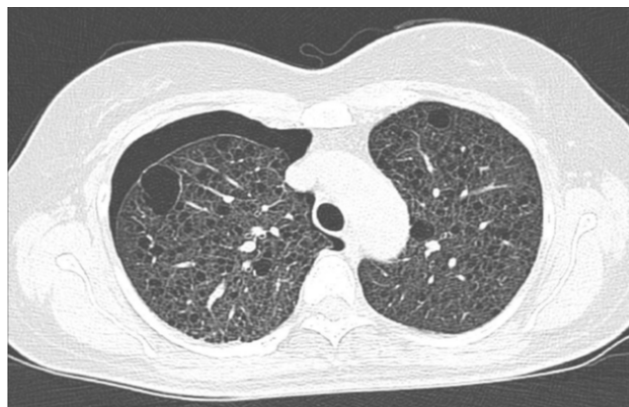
Chest CT scan showing multiple, well circumscribed, diffusely distributed thin walled varisized cysts ranging from 1-30mm in size with intervening normal lung, without lobar predominance.
